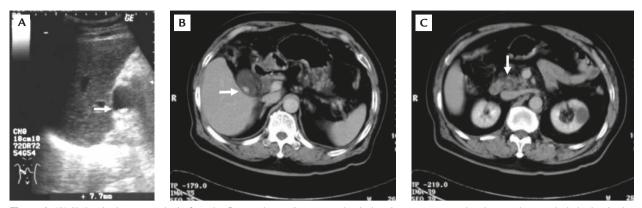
(A) Abdominal sonography before the first endoscopic retrograde cholangiopancreatography shows a hyperechoic lesion in the gallbladder with acoustic shadow (arrow). Computed tomography shows: (B) stones in the gallbladder (arrow); and (C) common bile duct stones (arrow).
